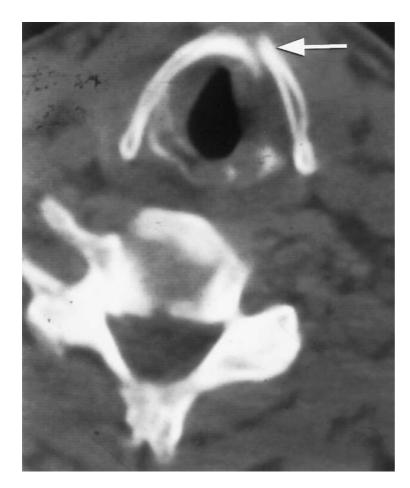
Laryngeal trauma. Axial computed tomography section through the subglottic space of the larynx defines a fracture in the anterior thyroid cartilage (arrow).
